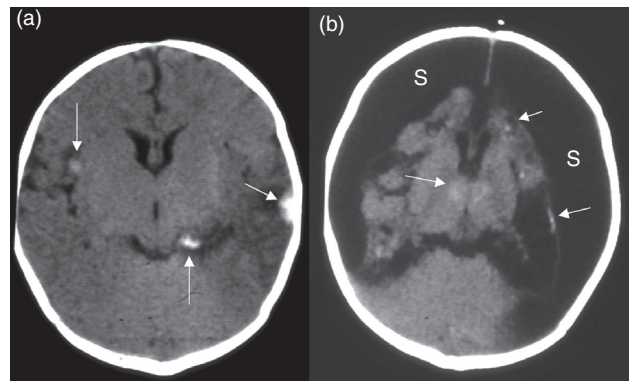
HSV2 encephalitis on CT: (a) subacute phase, including hemorrhages (arrows); (b) chronic phase, with encephalomalacia, subdural collections (s), and calcifications (arrows).
